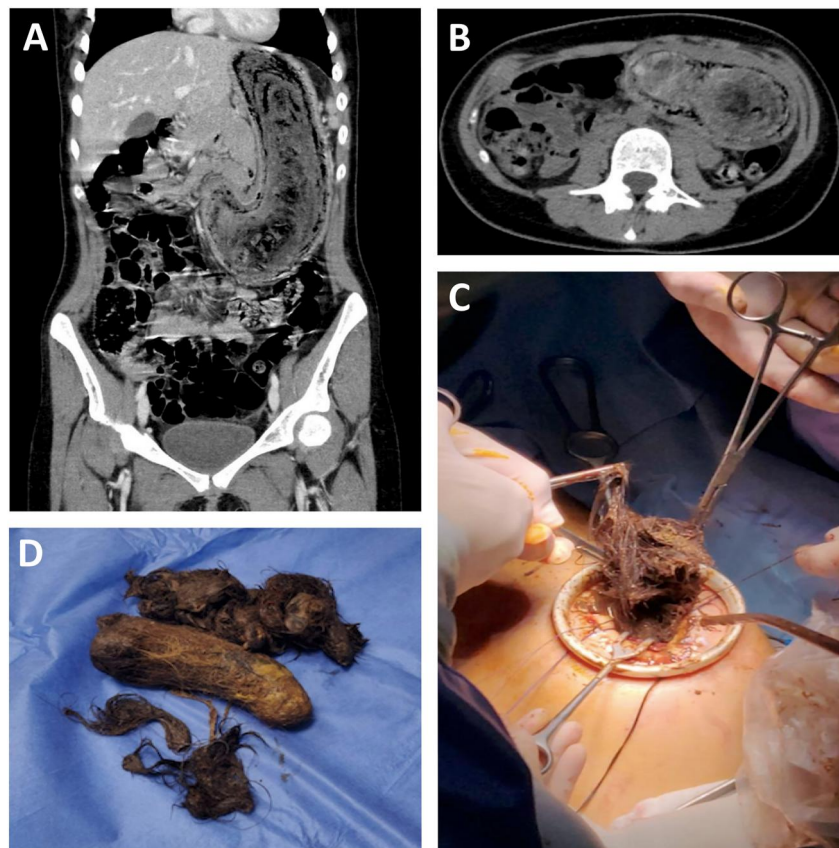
Axial (a) and coronal (b) computed tomography scan demonstrating a heterogeneous and multilayered gastric mass, molded by the stomach, extending into the first part of the duodenum, with a maximum diameter of about 4.5 cm, compatible with ingested material; (c) removal of the trichobezoar through laparotomic gastrotomy; (d) the recovered trichobezoar (approximate weight 500 g).
